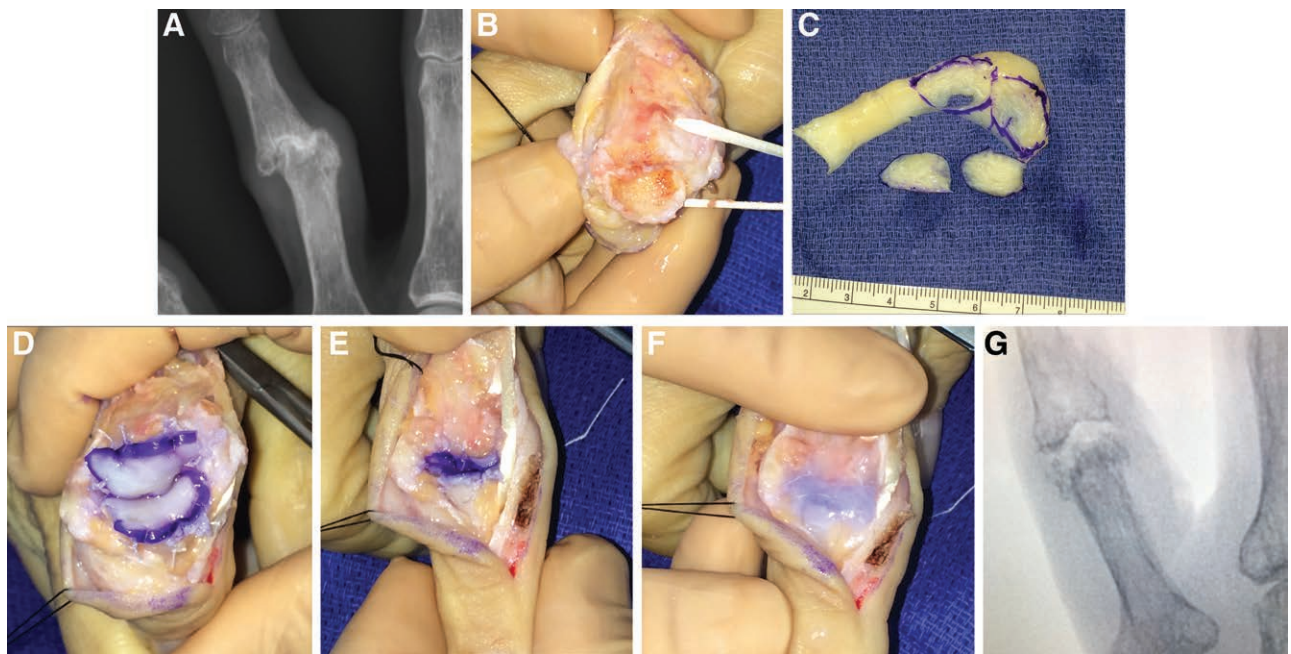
Intraoperative sequence for PIP arthroplasty of the left ring finger in an 81-year-old woman with osteoarthritis. A, Preoperative radiograph demonstrating joint destruction. B, Decorticated proximal and distal aspect of the joint. C, Meniscus allograft carved on the back table. D, Inset of the allograft over the proximal and distal aspects of the joint. E, Reduced joint. F, Joint sealed with fibrin glue. G, Postoperative radiograph demonstrating “cup and saucer” fit of the newly resurfaced joint.
